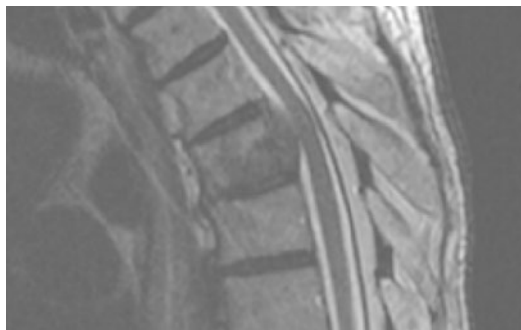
Sagittal MRI image of lytic lesion to T6 compressing the spinal cord
